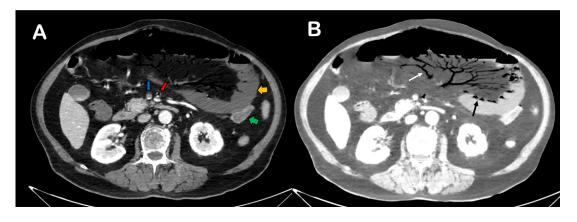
(A) CT axial image in the portal phase showing filling defect in both SMV (blue arrow) and SMA (red arrow), with the presence of gas within the latter. Moreover, the presence of small bowel loops with thinned walls and lack of enhancement (orange arrow) if compared to normal bowel (green arrow) is shown. (B) CT axial reformatted image with minimum intensity projection (minIP) highlighting the diffuse presence of intra-arterial mesenteric gas resembling the branches of a tree (white arrow), alongside the presence of gas within the bowel's wall (black arrow) consistent with pneumatosis intestinalis.
